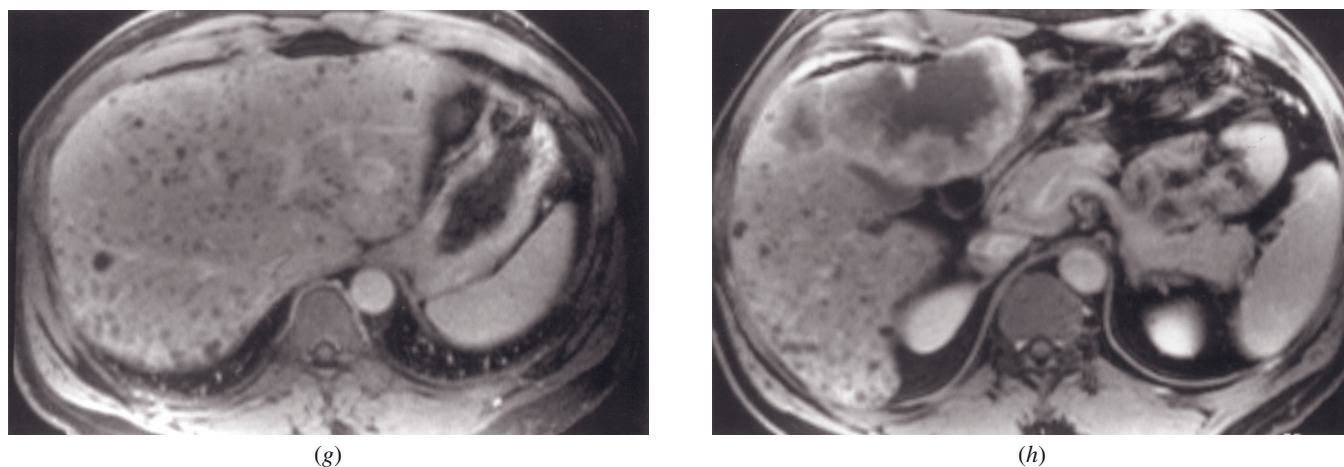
(Continued) T2-weighted image (*a*) and moderately low signal on T1-weighted image (*d*) and ring enhancement after administration of contrast (*f*, *h*), consistent with a metastasis. The liver is riddled with many small well-defined lesions, measuring <1 cm, that also demonstrate ring enhancement after contrast, consistent with biliary hamartomas. Note that the metastasis progresses in enhancement from early (*f*) to late (*h*) images, whereas biliary hamartomas show identical ring enhancement on early and late images with no progressive enhancement.
